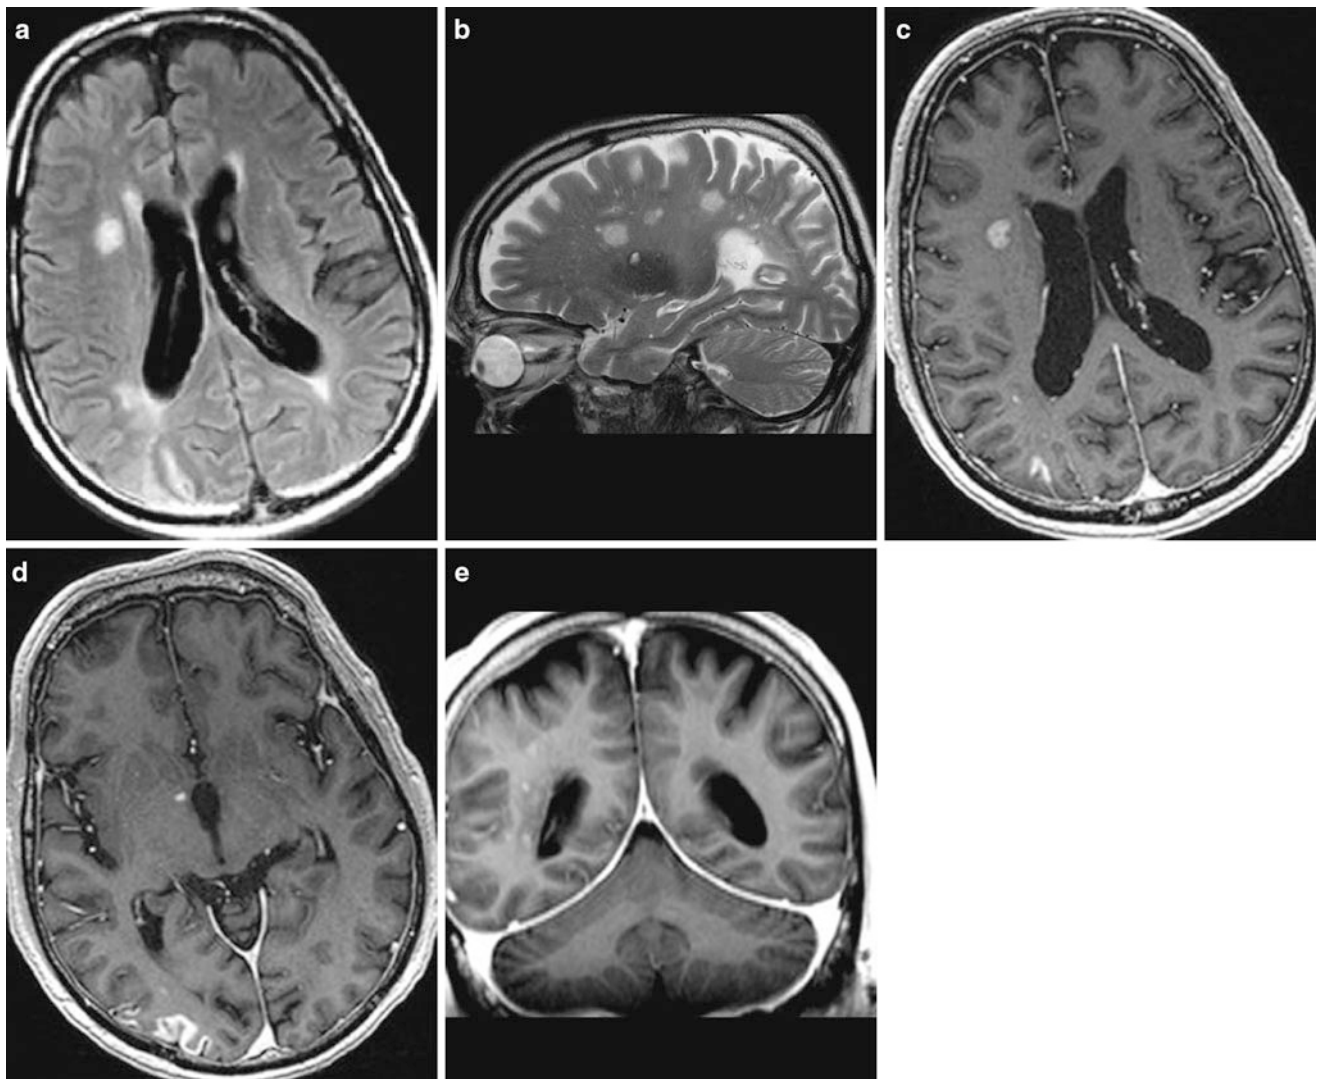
Panarteritis nodosa (PAN). A 65-year-old man with loss of vigilance and intermittent hemiparesis of the left side. Biopsy of the cerebellum and meninges yielded pathological features compatible with those of cerebral vasculitis. He died 3 months after hospital admission. a Axial FLAIR image. b Sagittal T2-weighted image. c, d Axial T1-weighted images after contrast administration. e Coronal T1-weighted image after contrast administration. Irregular subcortical and cortical signal changes of the right hemisphere (a). Patchy hyperintense areas on T2-weighted images in the right cerebral hemisphere (b). Multiple right-hemispheric contrast-enhancing lesions, patchy in the periventricular white matter and garland-like in the cortex of the right occipital cortex (c, d). Punctate nodular
